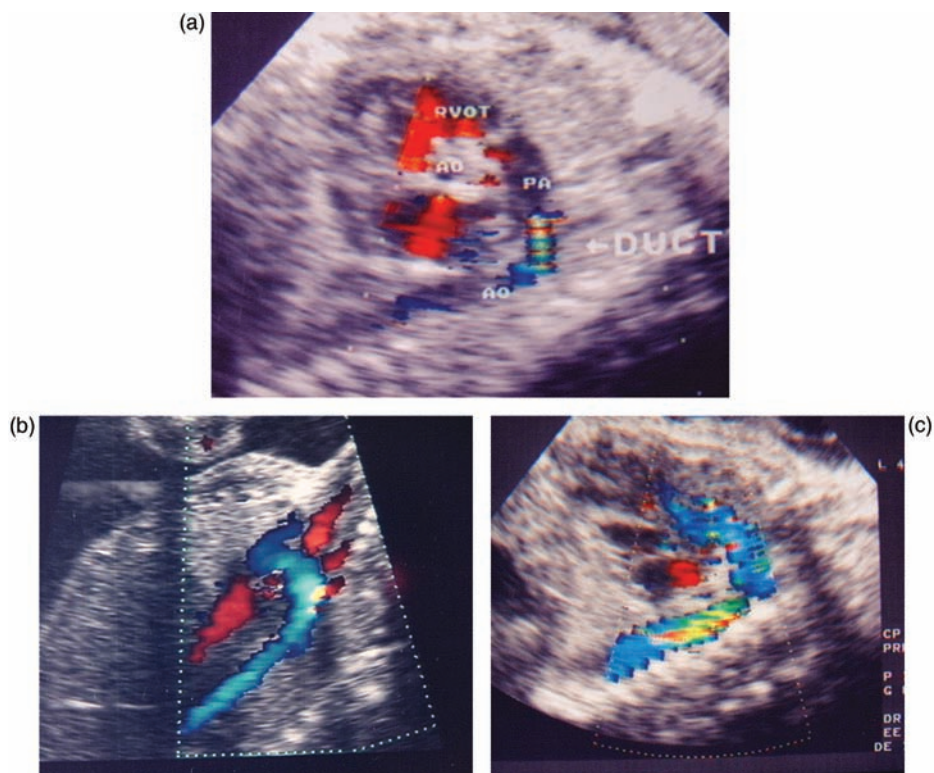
(a) Ductus arteriosus constriction under indometacin therapy. Color flow Doppler shows a turbulent ductal flow. (b) Normal aortic arch. (c) Coarctation of the Ao. Color flow detects a turbulent flow at the descending aorta.
